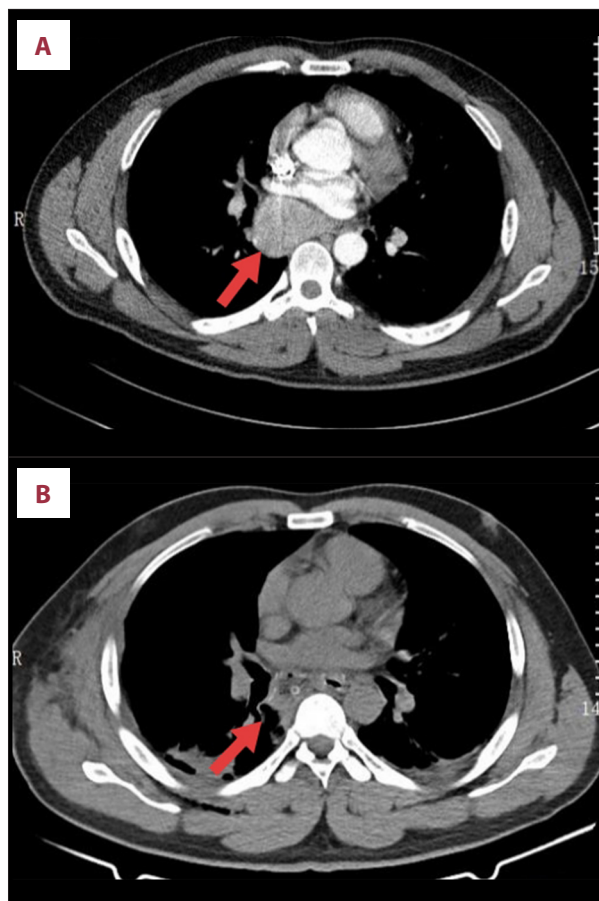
(A) Preoperative chest enhanced computed tomography revealed that the lesion was located below the tracheal carina and adjacent to the right main bronchus. (B) Postoperative chest computed tomography revealed complete resection of the mass. (C) Postoperative chest computed tomography scan 1 month later showed good recovery.
